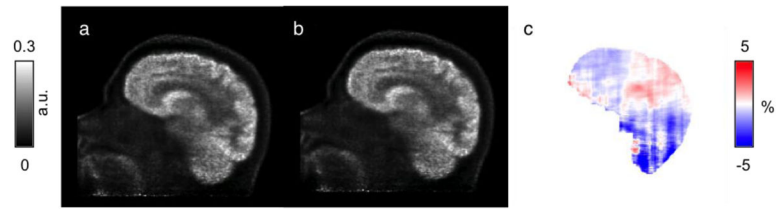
Representative PET images reconstructed with AC μ -maps derived from the scaled-CT method (PET_{CT}, a) and the PAC-map generation method (PET_{MR}, b). The corresponding RC map between the two PET reconstructions is shown in (c)
